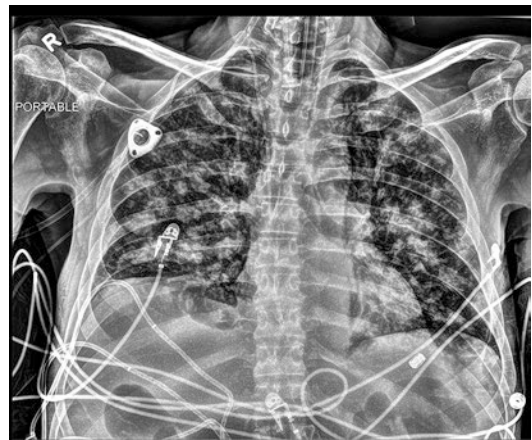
Chest X-ray of patient with metastatic cancer demonstrating significant pulmonary involvement
